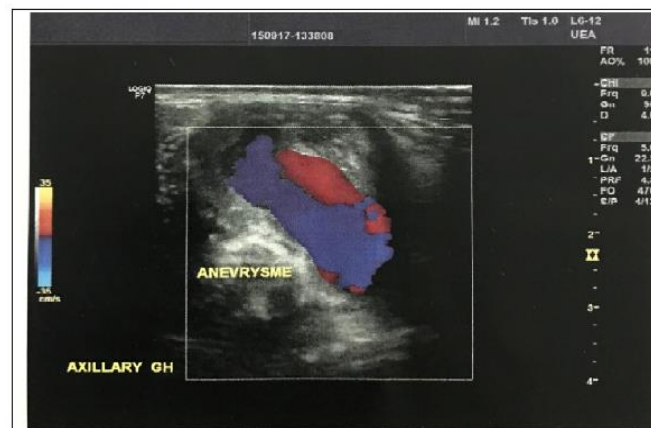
ultrasound coupled to Doppler:axillary aneurysm of left upper limb.
